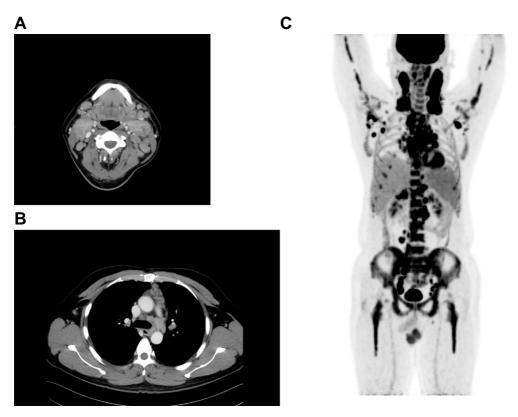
Imaging findings at ATLL relapse. (A, B) CT scan showing (A) multiple enlarged lymph nodes in the bilateral cervical region and (B) anterior mediastinal masses. (C) PET-CT scan showing an increased accumulation of ¹⁸F-FDG in the bilateral cervical, supraclavicular fossa, mediastinal, paraaortic, and bilateral common iliac artery lymph nodes.
